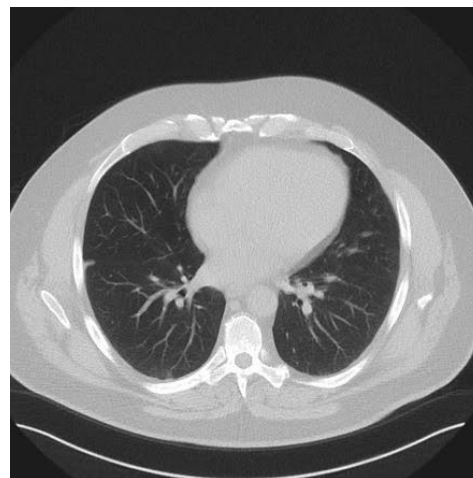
Follow-up HRCT Thorax (axial section) performed 15 days after initiation of Oseltamivir
